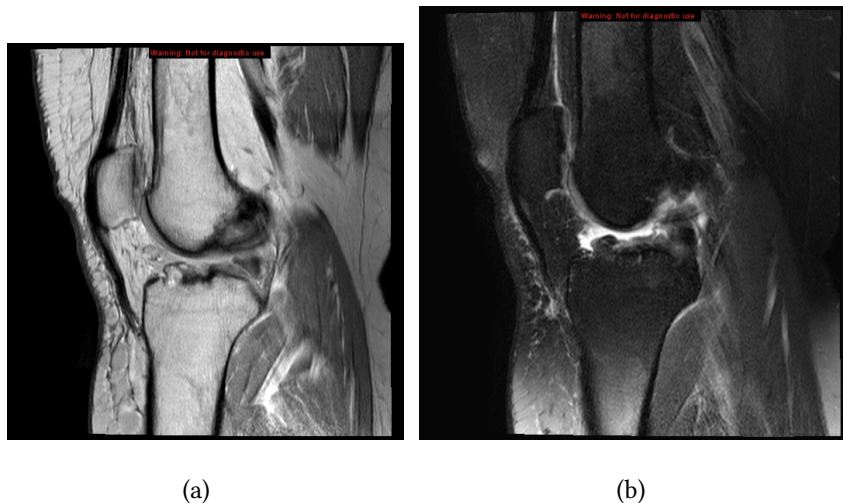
(a) ACL tear seen in a PD MRI. (b) ACL tear seen on a T2 MRI. Both using a sagittal view *Source: Case courtesy of Hani Makky Al Salam, Radiopaedia.org, rID: 12175* [21]
